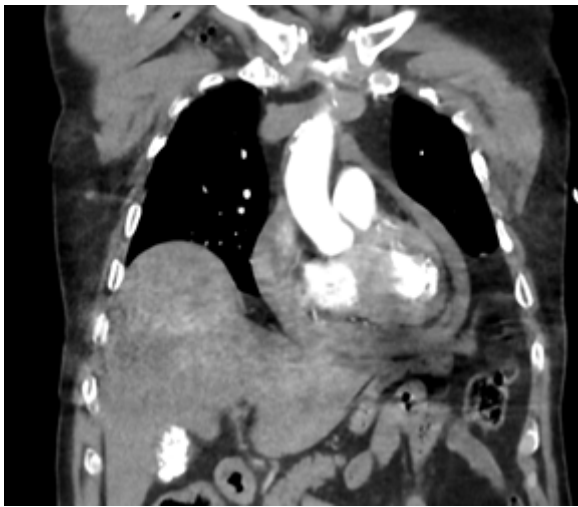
Image of pericardial effusion on CT.
